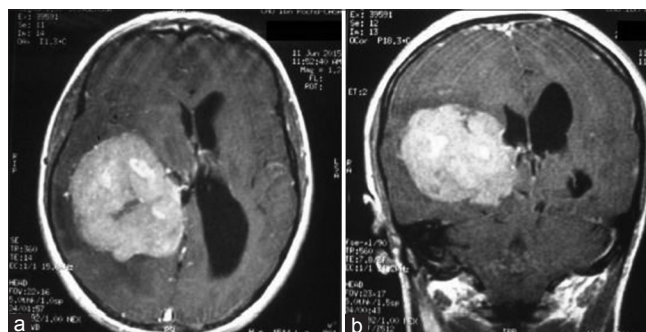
Cerebral magnetic resonance imaging after gadolinium in axial (a) and coronal (b) view showing meningioma attached to the ventricular wall
